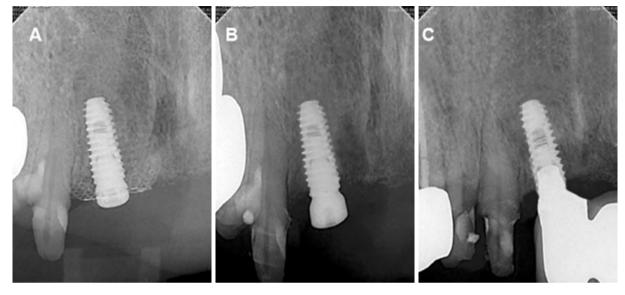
Comparison of periapical radiographs taken at the application (A) and removal (B) of the preformed titanium mesh and at 1 year after delivery of the final prosthesis (C).
